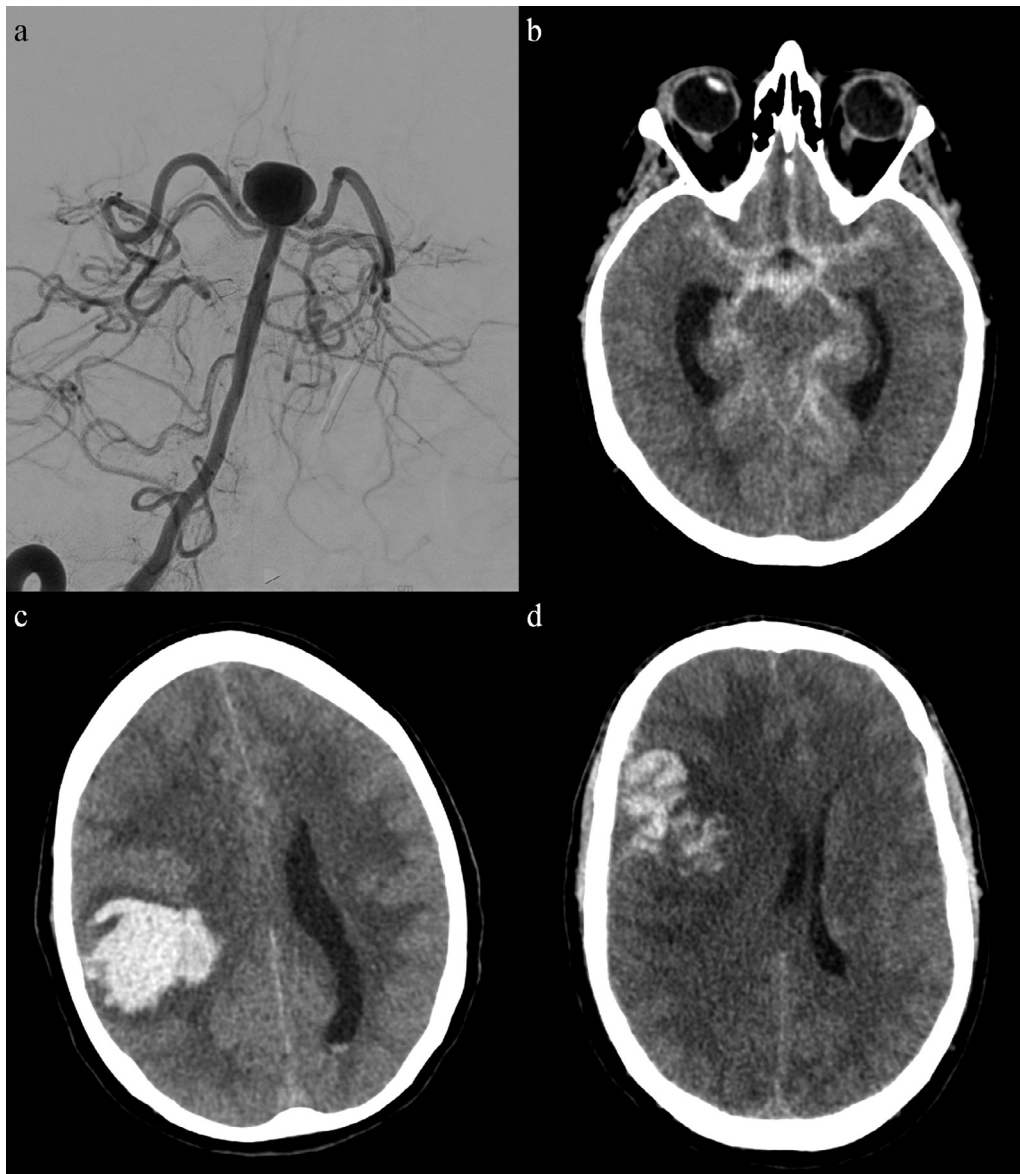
A right vertebral artery digital subtraction angiogram showing a 1cm basilar artery apex aneurysm (a) and an axial non-contrast computed tomography (CT) scan showing diffuse subarachnoid hemorrhage in the basal cisterns (b) for case 1. A CT scan of case 2 showing a large right sided intraparenchymal hemorrhage with significant mass effect, cerebral edema, effacement of the right lateral ventricle, midline shift, and intraventricular hemorrhage (c). A CT scan of case 3 showing a right frontal hemorrhagic tumor with associated mass effect and midline shift (d).
